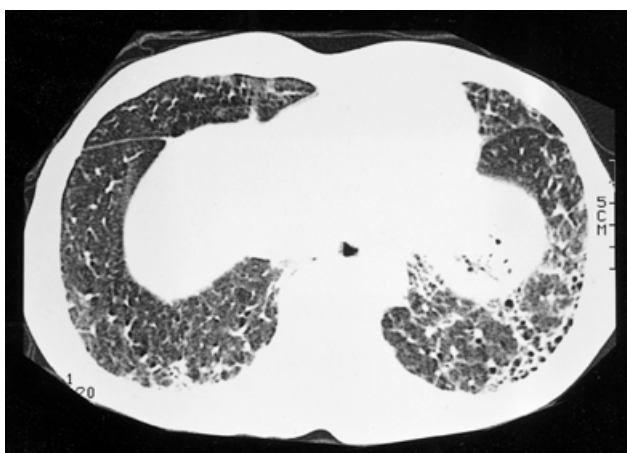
Chest computed tomography scan. Note the ground-glass opacities and honeycomb formations in the lower lung fields bilaterally.
